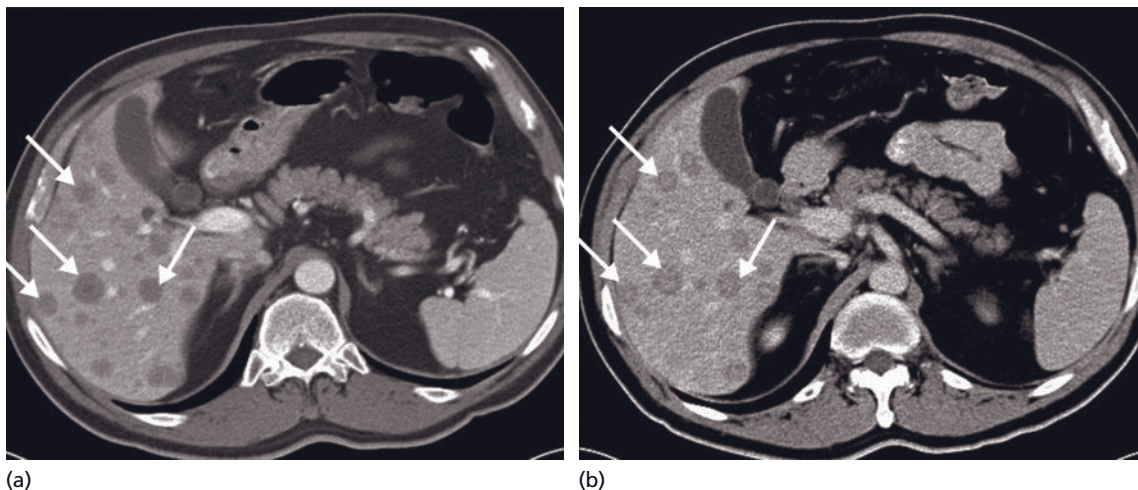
Hypovascular metastases. (a) Portal-venous and (b) delayed-phase contrast-enhanced CT images demonstrate multiple hypoenhancing colon carcinoma metastases (arrows). On the delayed image (b), several metastases show the “peripheral washout sign”, i.e., central hyperdensity with peripheral hypodensity (arrows).
